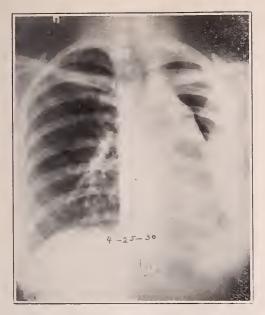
Case IX, roentgenogram showing conditions after intrapleural pneumolysis had freed adhesions and allowed satisfactory collapse of upper lobe cavity.
